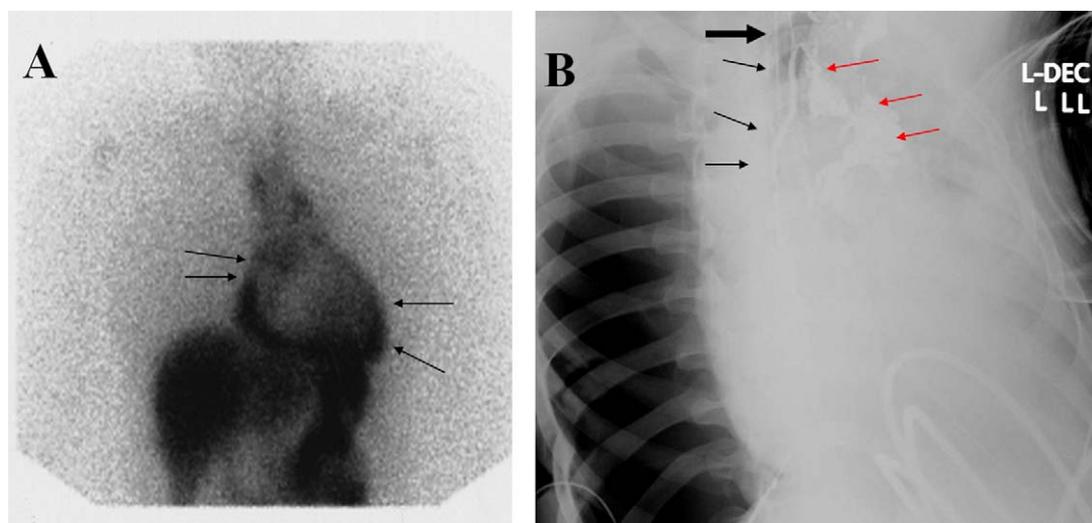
(A) ¹²³I-BMIPP lymphoscintigraphy shows accumulation of ¹²³I-BMIPP in the pericardial sac (arrows). (B) Intraoperative thoracic duct angiography demonstrated abnormal reflux of the contrast dye into the pericardium. Black arrows indicate the thoracic duct. A large black arrow indicates the obstruction of the thoracic duct. Red arrows indicate abnormal reflux of the contrast dye through lymphatic channels.
